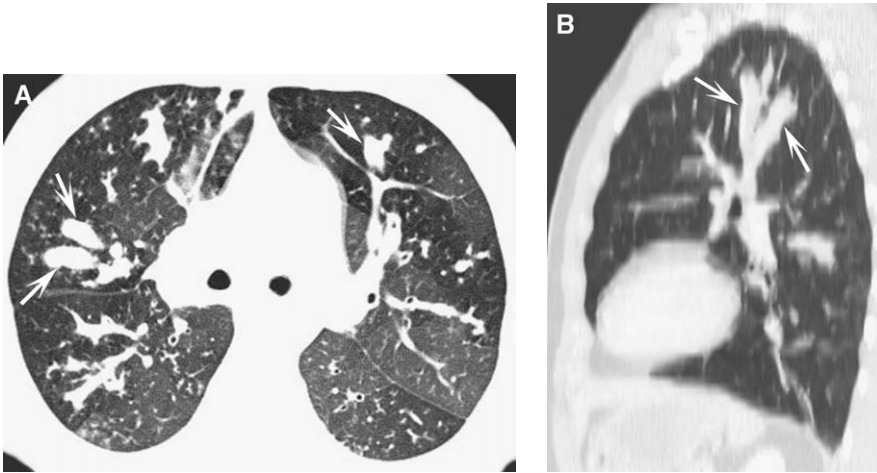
HRCT assessment of bronchiectasis: mucoid impaction. (A) Axial HRCT image shows extensive, bilateral mucoid impaction (arrows). Bilateral inhomogeneous lung opacity represents mosaic perfusion caused by large and small airway obstruction. Small centrilobular nodules are visible in the right lower lobe. (B) Sagittal maximum intensity projected image shows the mucoid impaction (arrows) to advantage; “finger-in-glove” appearance is clear.
